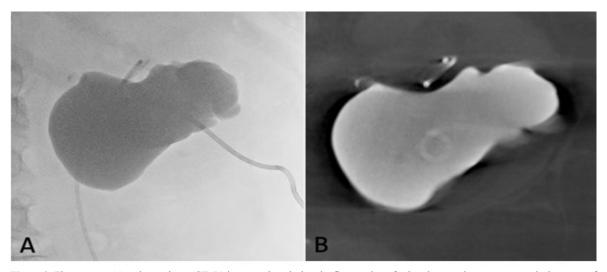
Fluoroscopy (a) and cone-beam CT (b) images taken during the first session of sclerotherapy show no contrast leakage out of the cyst.
